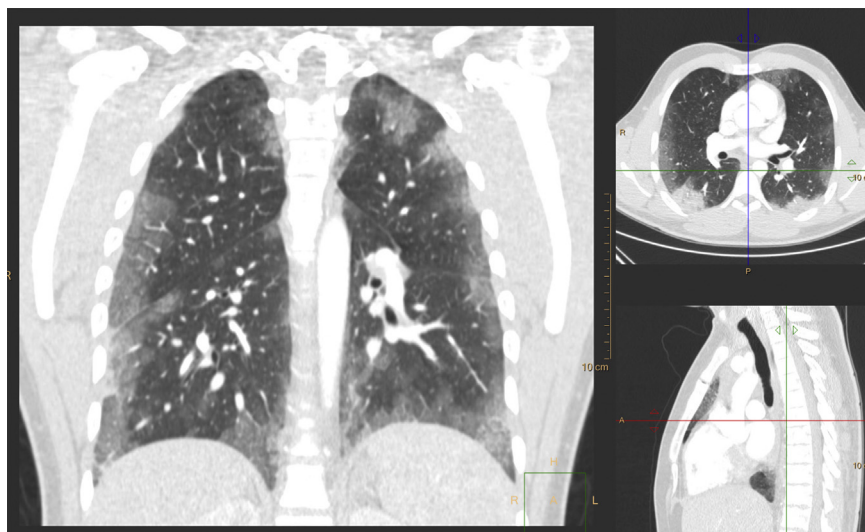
HRCT showed large areas with ground glass opacities in the periphery of the lung parenchyma.
